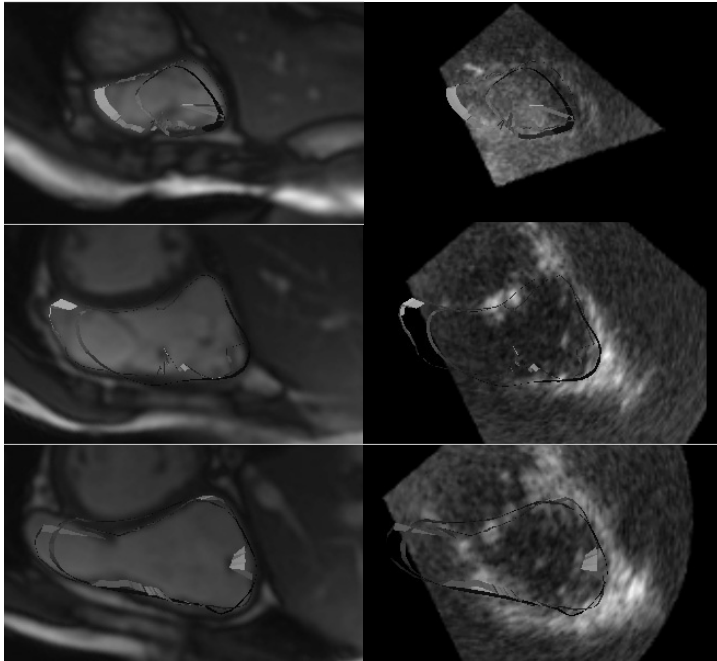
Display of the right ventricle in short-axis views, at the basal, mid and apical level, displayed by cardiac magnetic resonance imaging (left) and real-time 3-dimensional echocardiography (right), with the magnetic resonance contours in green and the real-time 3-dimensional echo contours in different colors.
